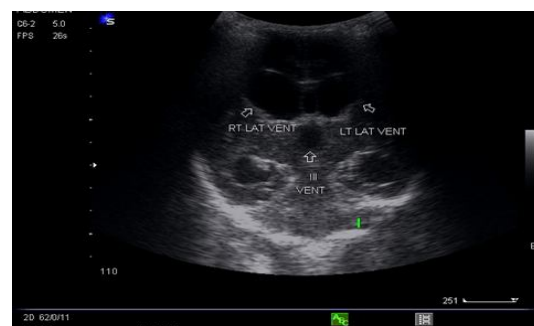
Neurosonography showing dilated lateral ventricles and IIIrd ventricle suggestive of aqueductal stenosis
